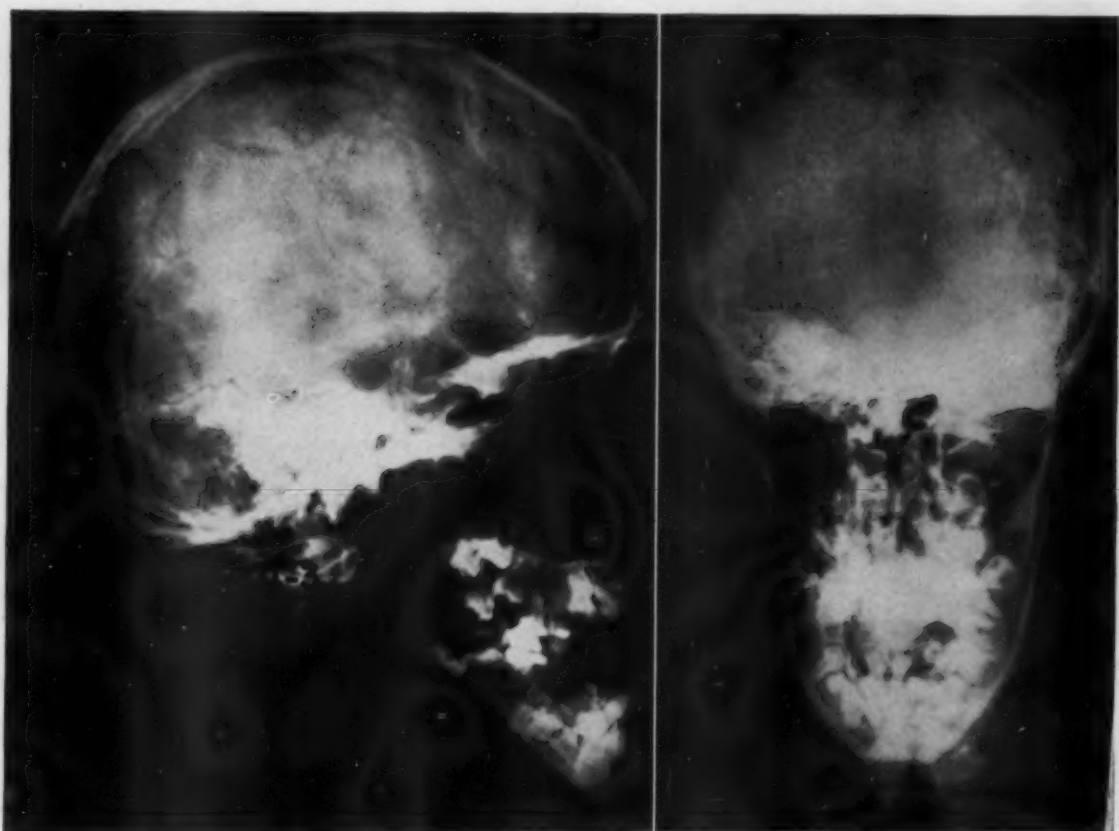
X-rays of skull showing open sutures and wormian bones. Sib. II-3.
